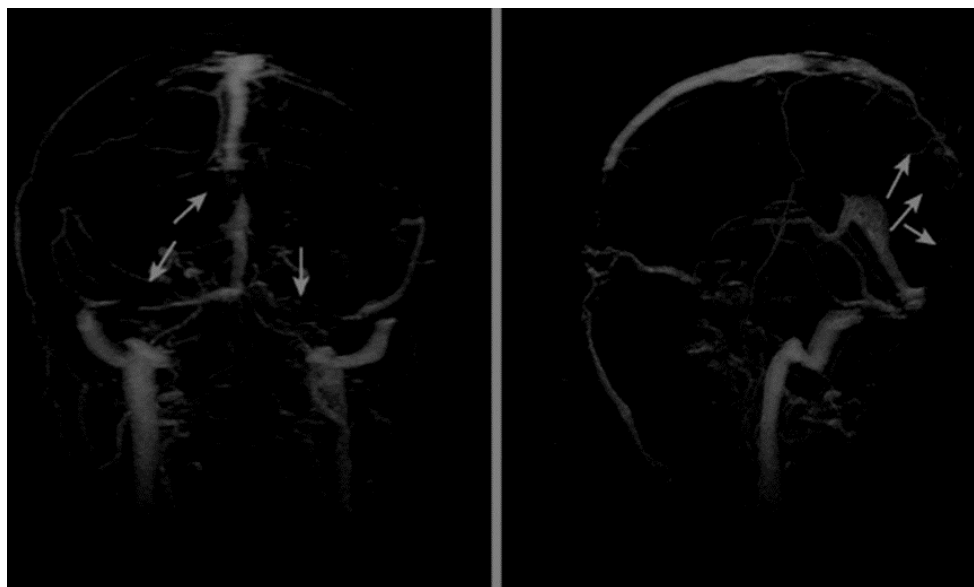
MRI with MRV brain showing Thrombosis of the Superior Sagittal, Straight, and Transverse Sinuses
